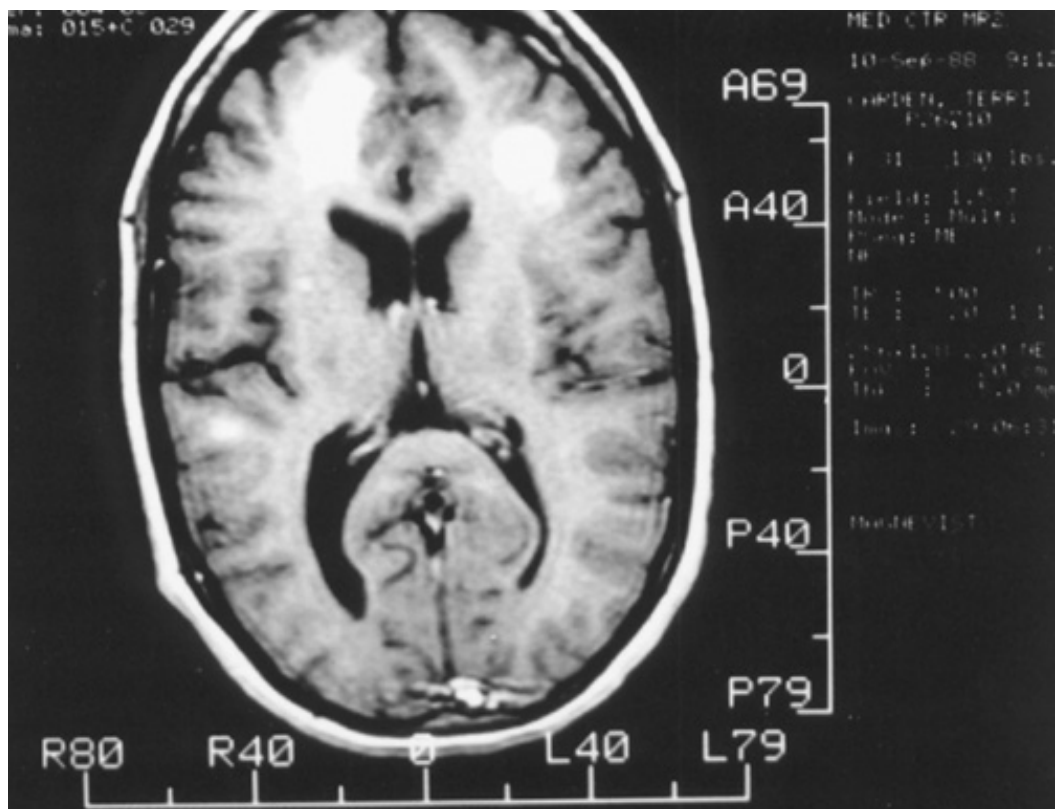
Magnetic resonance image of the brain in a patient with acute left-sided *Staphylococcus aureus* endocarditis, showing multiple areas of focal cerebritis. This patient had no focal central nervous system signs and recovered fully with antimicrobial therapy. (MRI by courtesy of the Department of Radiology, Duke University, Durham, NC.)
